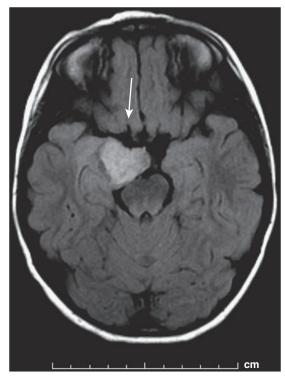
The magnetic resonance imaging scan of the child whose EEG is depicted in the previous four figures demonstrates the causative lesion. A glioma enlarging the tip of the right temporal pole is seen on this fluid-attenuated inversion recovery image (arrow). This unilateral lesion was responsible for generating a discharge which, at times, was indistinguishable from generalized spike wave.
